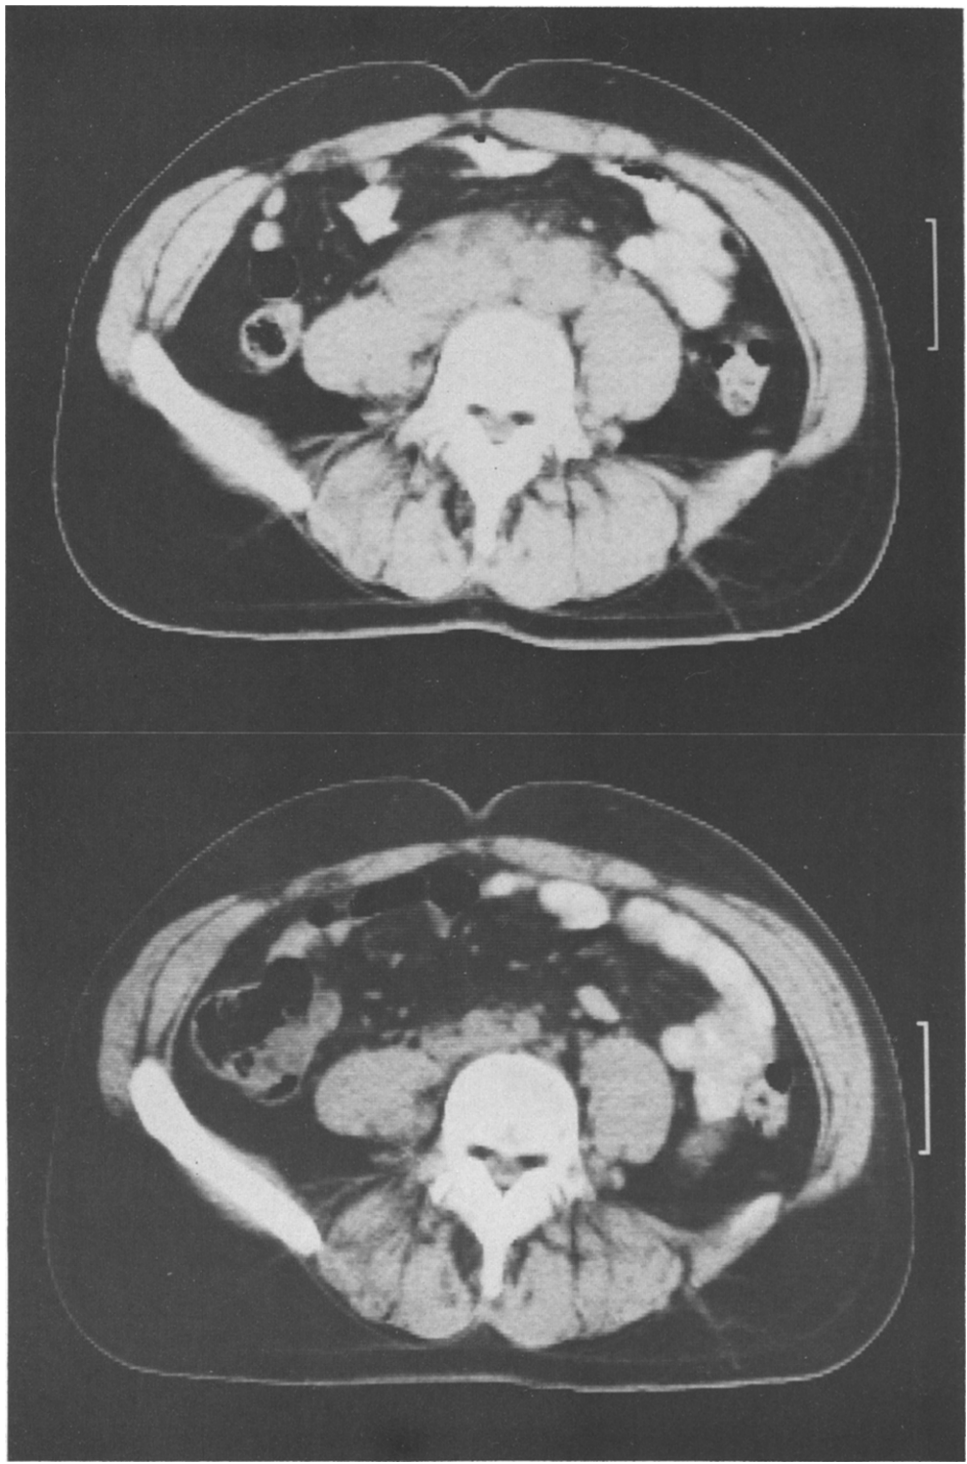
Abdominal CT scan demonstrating a complete response of retroperitoneal lymph node metastases to high-dose ketoconazole in a patient with prostate cancer (patient no. 6).
